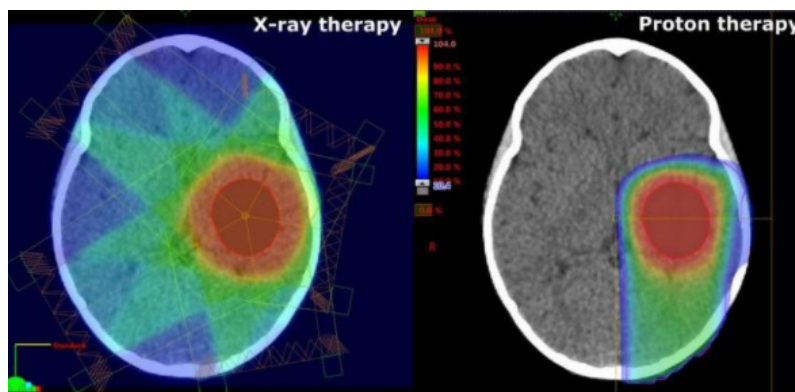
Dose delivery to the tumor region for x-rays (left) and protons (right). To deliver high doses (red) to the tumor region in x-ray therapy, the patient has to be irradiated from several angles. In proton therapy, less irradiation directions are necessary to deliver the same dose to the tumor, which leads to reduced overall dose delivered to healthy tissue [11].
